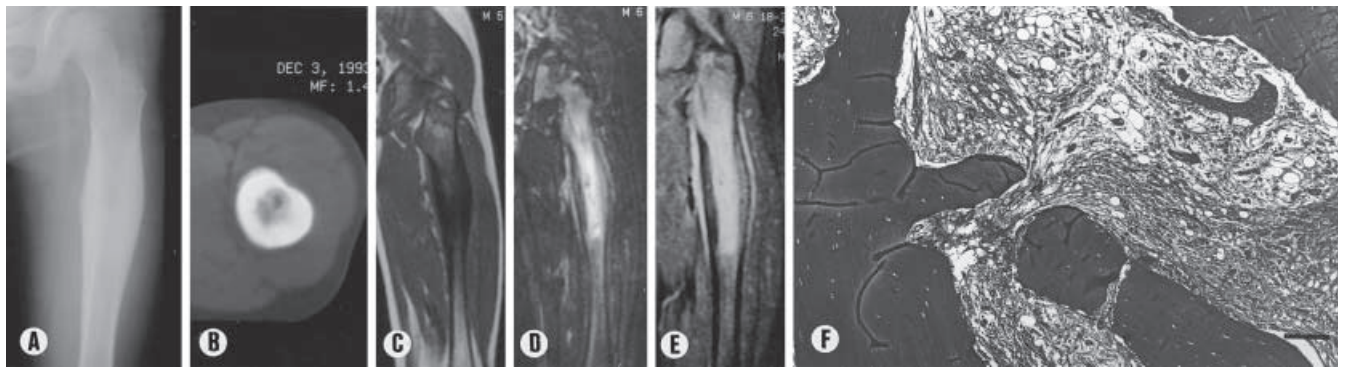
Case 1. Plain radiography (A) and computed tomography (CT) scan (B) show hyperostosis of femoral shaft. On magnetic resonance imaging (MRI), the lesion shows low signal intensity on T₁-weighted image (WI) (C), high signal intensity on short tau inversion recovery
